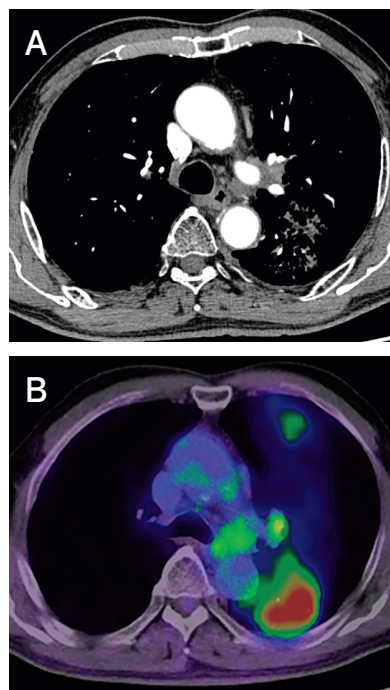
Image analyses after induction chemoradiotherapy. (A) A CT scan of the chest. (B) A PET-CT scan. The lung tumor and swollen lymph node are remarkably reduced in size (decreased uptake of ^{18}F -fluorodeoxyglucose). Radiation pneumonitis is visible in the left lower lobe.
